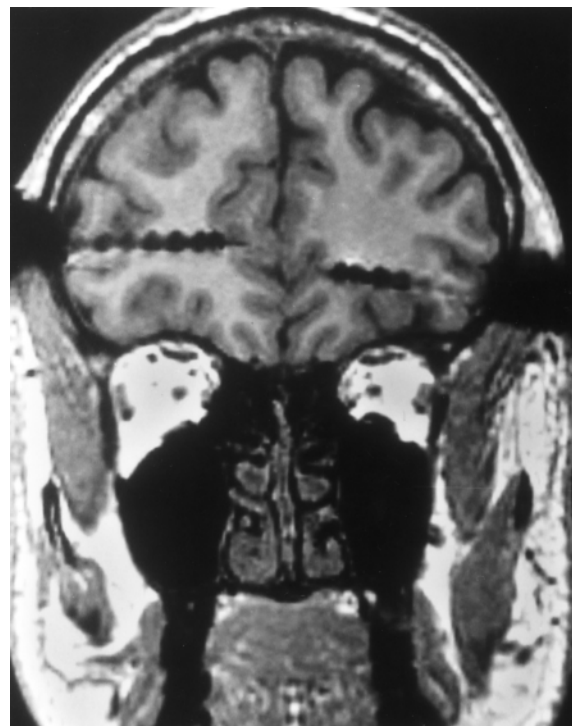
Coronal MR image (spoiled-gradient sequence on 1.5-tesla imager) demonstrating intracranial depth electrodes placed in the ventromedial frontal cortex of a patient with epilepsy. The contacts for EEG recording along the shaft of each electrode create an MR artifact that is larger than the actual diameter of the probe (1.3 mm). The guide screws at the entry sites also create MR artifacts that are considerably larger than the twist-drill hole used for placement of each electrode. The distal end of the electrode on the right side includes a microdialysis membrane and platinum-iridium microwires, whereas the distal end of the electrode on the left side includes only microwires.
